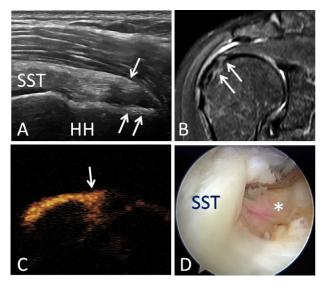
Large bursal-side partial-thickness tear in a 51-y-old woman. (A) Ultrasound revealed a local defect area with an extension through both the articular and bursal surfaces of the supraspinatus tendon (\\(\backsq\\)) and hyper-echoic peribursal fat filling a small superficial defect (\(\backsq\)) in the long-axis view. (B) An oblique coronal T2-weighted image revealed a brighter signal on the articular side of the involved tendon (\(\backsq\\\)). (C) Percutaneous ultrasound-guided subacromial bursography image revealed contrast agent filling and outlining the torn tendon (\(\backsq\\)) located only at the bursal-side cuff in the long-axis view. (D) Arthroscopy confirmed a large bursal-side partial-thickness tear with only a membrane-like residual on the articular side
